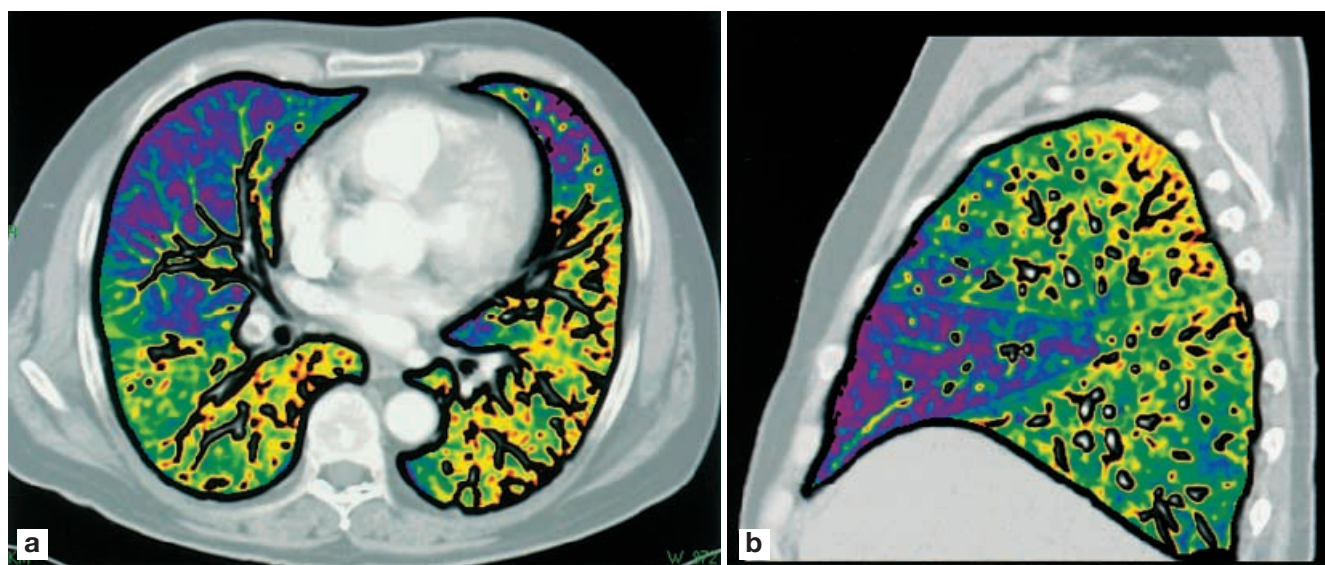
A 58-year-old man with PE in the right middle lobe. a Perfusion-weighted color-coded display of a transaxial, contrast-enhanced multislice CT data set enables delineation of the resulting perfusion defect in the dependent parenchyma. Perfusion-weighted display allows estimating the percentage of lung parenchyma that is functionally affected by thromboembolism. Superimposing functional data on the morphological scan aids spatial orientation. b Reconstruction of functional image data in the sagittal imaging plane is made feasible by the isotropic nature of a high-resolution multislice CT data set and further aids localization and visualization of perfusion defects. In addition, on reformats in arbitrary image orientations gravity-dependent distribution of lung perfusion can be more accurately assessed and better differentiated from embolic perfusion deficits compared with transaxial scans alone
